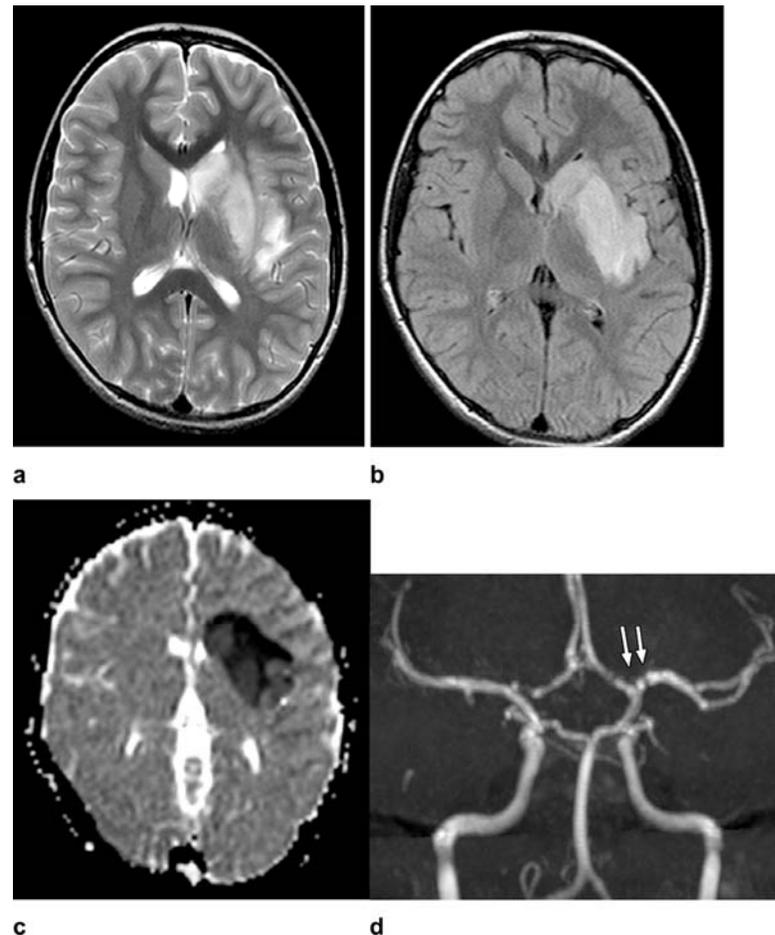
Axial T2-weighted (a) and FLAIR (b) Magnetic resonance imaging show diffuse hyperintense signal and edema of the caudate nucleus head, putamen, anterior limb of the internal capsule, and parts of external capsule and insula on the left side, with corresponding low values on the axial apparent diffusion coefficient map, in keeping with an acute infarct. Time-of-flight magnetic resonance angiography maximal intensity projection reformatted image demonstrates focal irregular narrowing and banding of the proximal left M1 segment of the middle cerebral artery with a slightly reduced distal flow in the middle cerebral artery.
